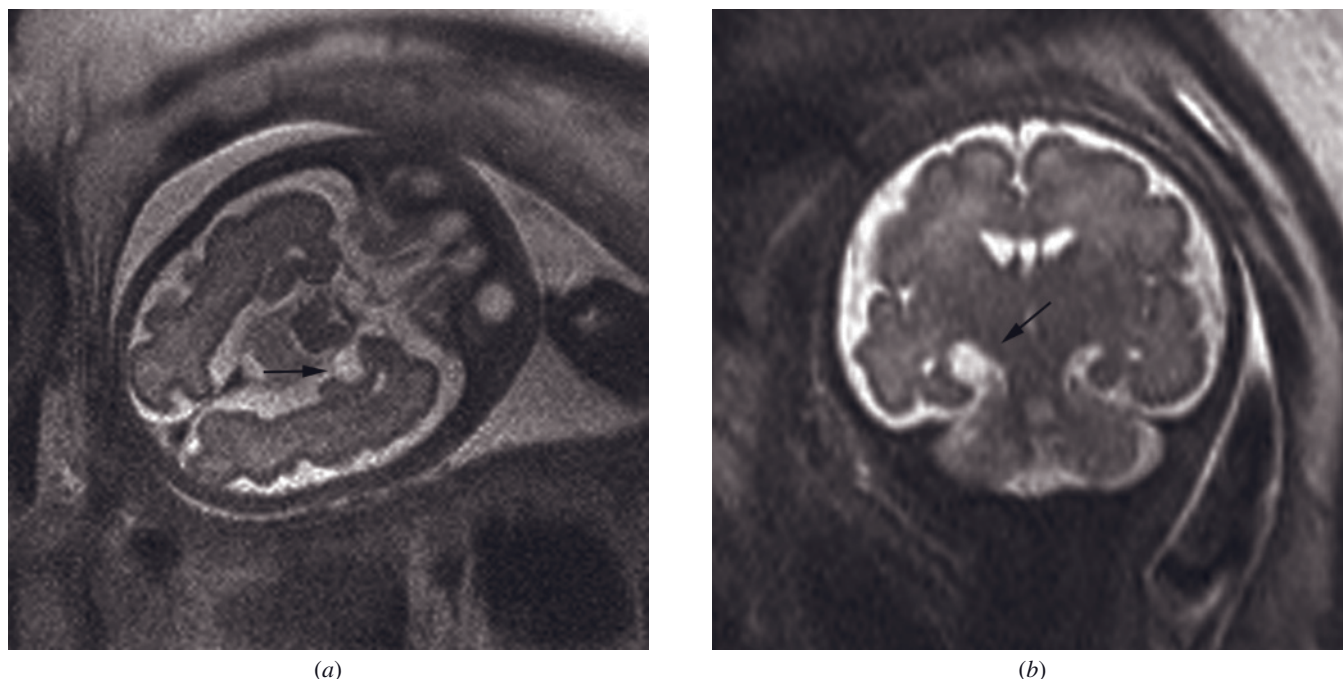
Arachnoid cyst of choroidal fissure. Transverse (a) and coronal (b) T2-weighted SS-ETSE images of the fetal brain at 34 weeks demonstrates a well-circumscribed, extra-axial, hyperintense cyst in the right choroidal fissure, consistent with an arachnoid cyst.
